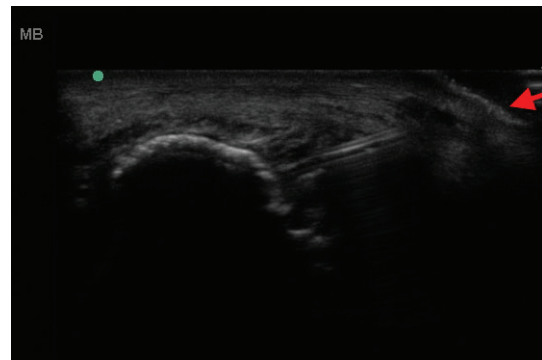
Debridement probe localized within the lesion with ultrasound guidance.
